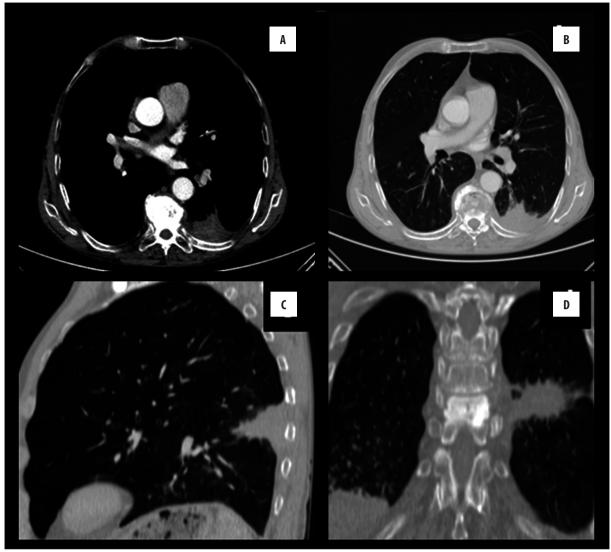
(A, B) Contrast enhanced axial CT scan of the thorax, (C) sagital reformatted and (D) coronal reformatted CT scan of the thorax shows pleura-based consolidated lesion with spiculated contours in the superior segment of the right lower lung lobe.
